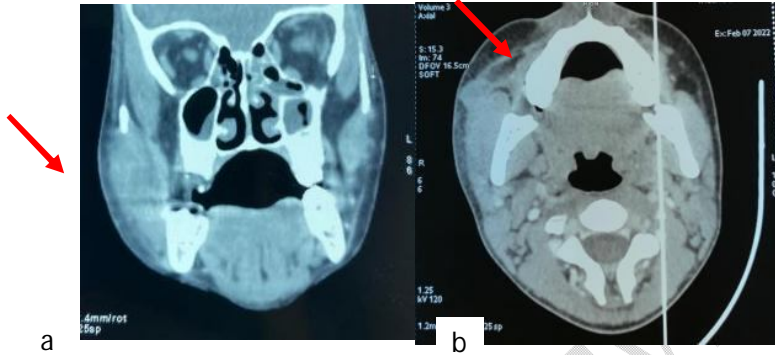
CT scan head and neck with contrast at initial presentation
